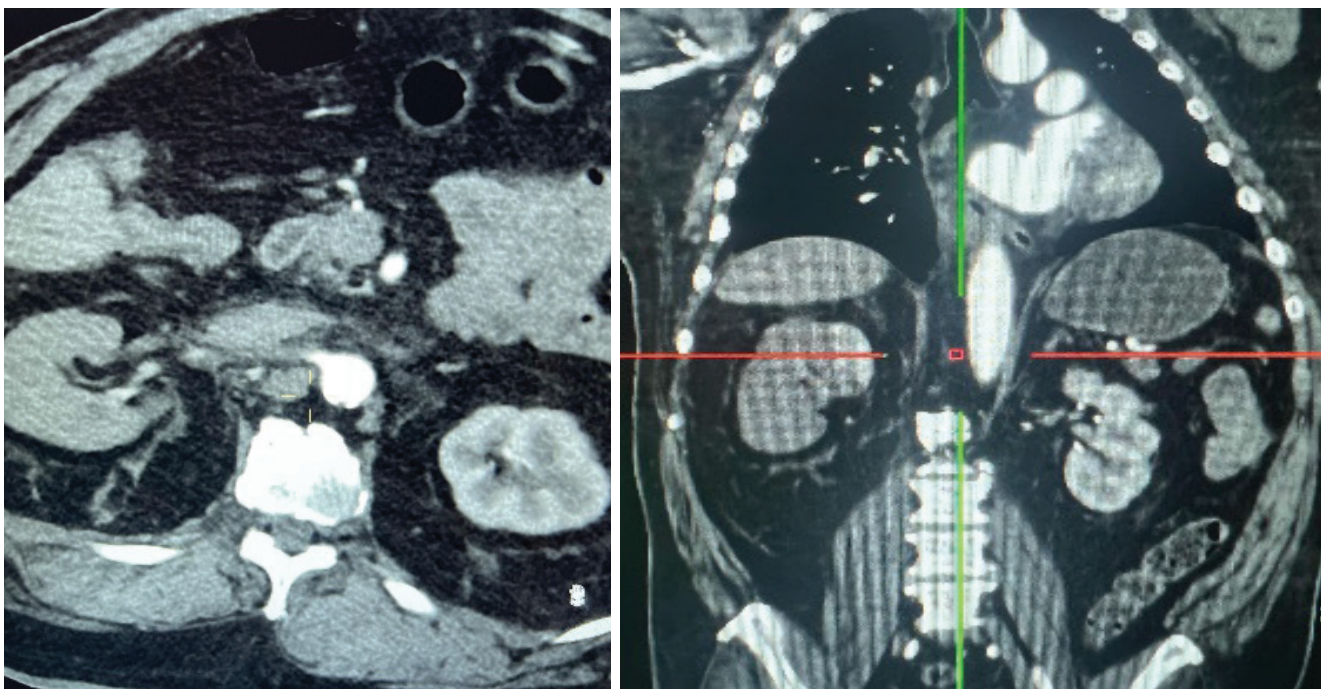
CT - scanner showing a perfused left kidney and perfused only upper pole of right kidney.
